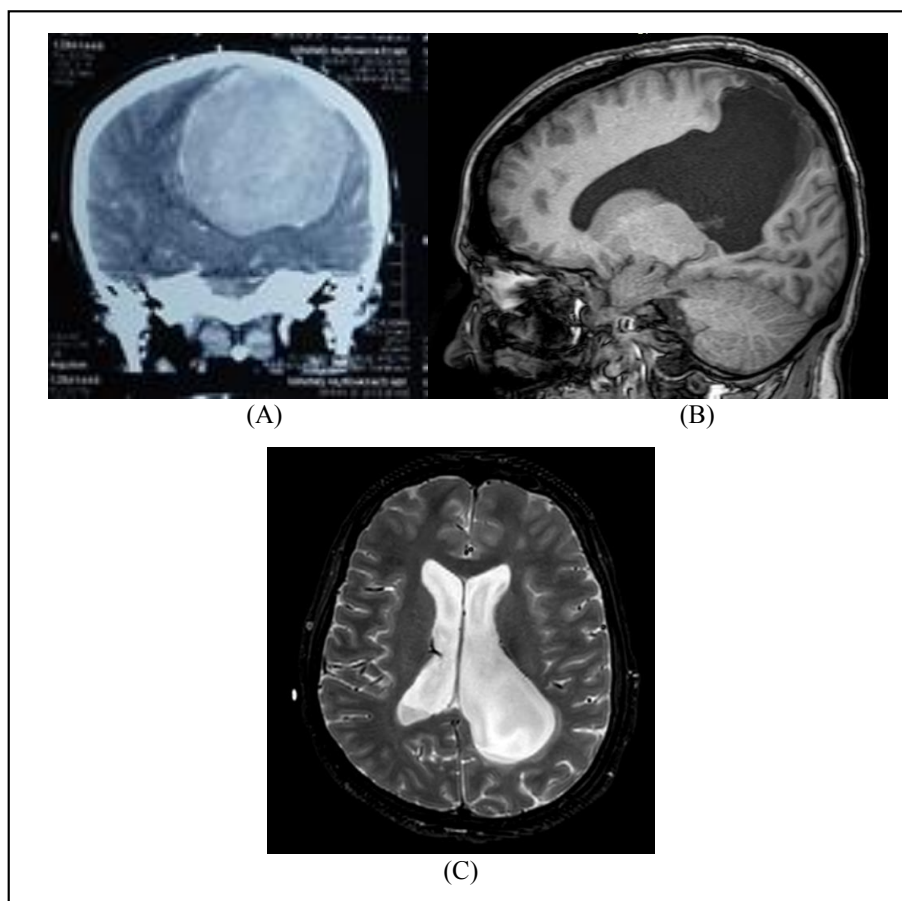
(A) Head CT scan showed extra-axial meningioma. (B, C) T1/T2 Weighted MRI showed porencephaly, hydrocephalus, and midline shift after meningioma resection.
